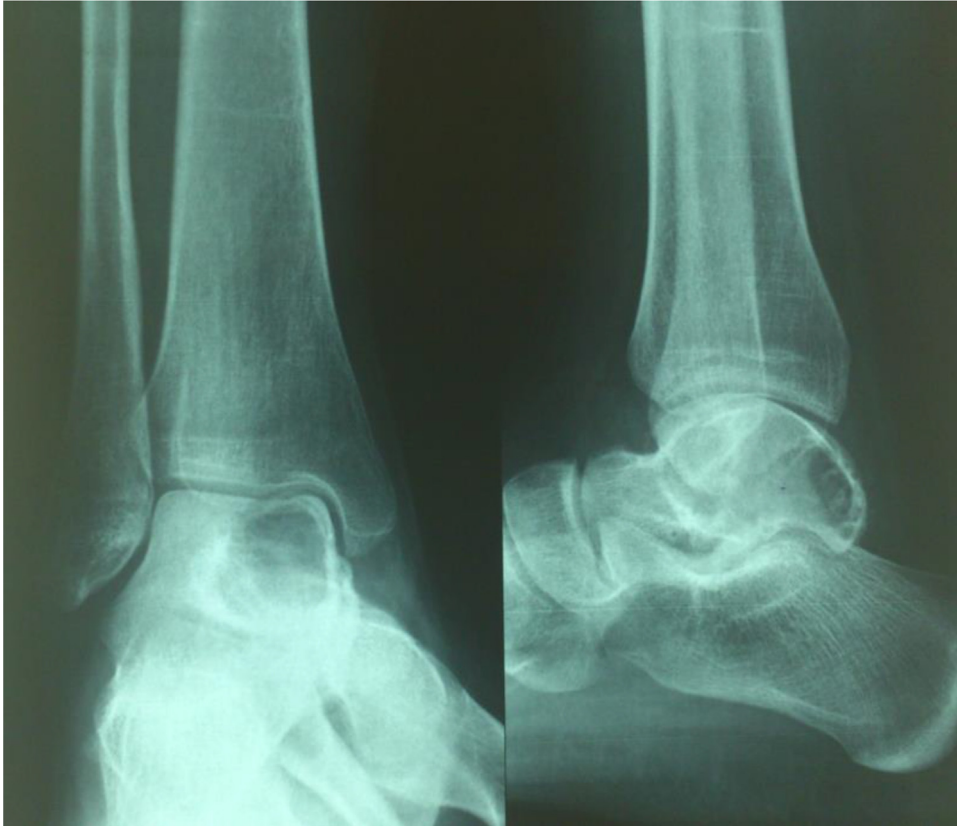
Radiograph of the right ankle showing a lytic lesion in the talus.
